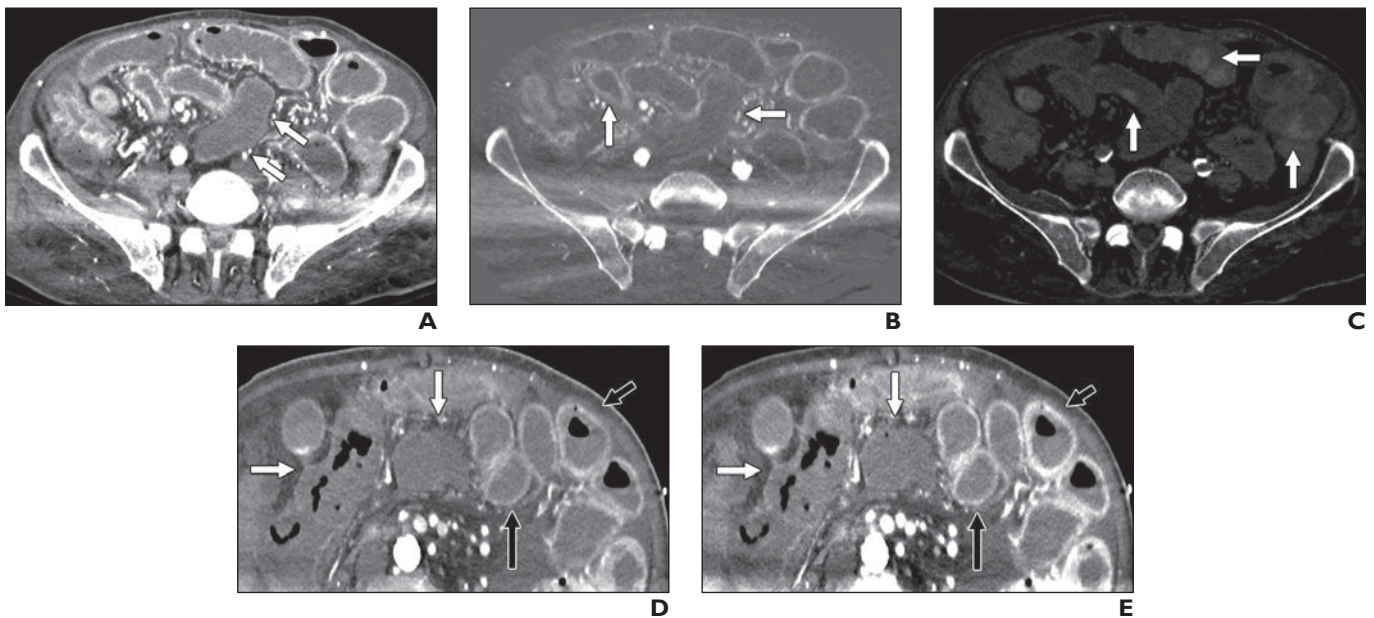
82-year-old patient with nonocclusive mesenteric ischemia after cardiac surgery. Evaluation was performed by dual-energy CT. A, Axial arterial phase CT image obtained at 50 keV shows hypoenhancing loop of small bowel in midabdomen (arrows). B, Iodine-only arterial phase CT image obtained at 50 keV shows increased conspicuity of small-bowel hypoenhancement relative to adjacent loops of bowel (arrows). C, Virtual noncontrast CT image obtained at same level as A and B shows intraluminal high-attenuation hemorrhage in multiple loops of small bowel (arrows). D, Conventional linear blend arterial phase CT image shows small-bowel mural thickening, hypoenhancement, and ascites. Black arrows show enhancing, perfused loops of small bowel. White arrows highlight loops of poorly enhancing, ischemic bowel. E, Dual-energy CT image obtained at 50 keV and at same level as D again shows small-bowel mural thickening and hypoenhancement. Images scanned at 50 keV, near k-edge of iodine, accentuate differences in bowel mural enhancement. Black arrows show enhancing, perfused loops of small bowel. White arrows highlight loops of poorly enhancing, ischemic bowel.
